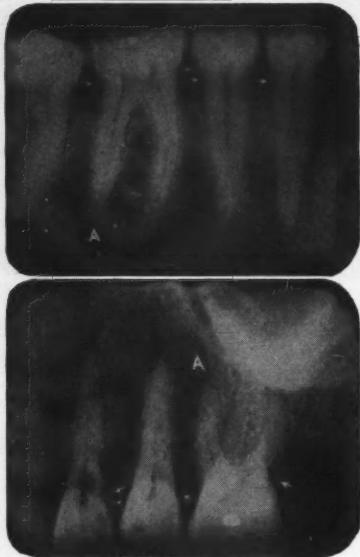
Simplex periodontitis in patient, aged 50. Representative of all other teeth in the mouth. Note how the lamina dura follows the tooth in a normal relation about the apex. Observe the fine closely knitted trabeculae forming a network of criss-cross bone cells. The alveolar ridge is evenly resorbed throughout the mouth. Note the calculus deposits about the root surfaces. Also note the smooth even wearing of the occlusal surfaces of the enamel. This patient has recently been referred for periodontal treatment. Three years ago she was told by her dentist that she had pyorrhea and that it was incurable; therefore she should have all her teeth extracted. Clinically the gingivae were puffed and hypertrophied, purplish, and free pus exuded from all the pockets. This type of case responds readily to treatment. A, Compare the clinical and roentgenographic evidence with Figs. 1 and 2. A, Closely knit trabeculae. Arrows point to calculus.
